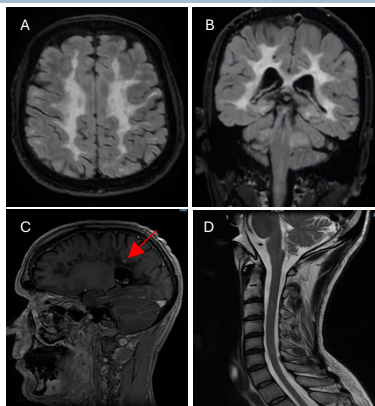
A) 3D FLAIR in axial section; B) 3D FLAIR in coronal section; C) 3 mm contrast-enhancing lesion on T1w with gadolinium highlighted by the red arrow; D) Spinal cord lesions. T2 sagittal plane.
